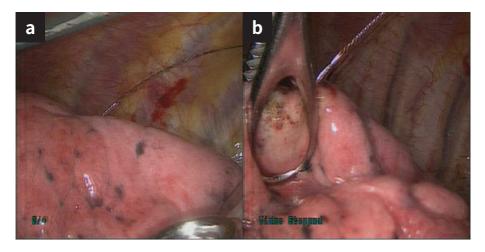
Wire-localization of the LLL lesion.(a) the wire was set with the assistance of CT. (b) the lesion was grasped with a ring forcep.
